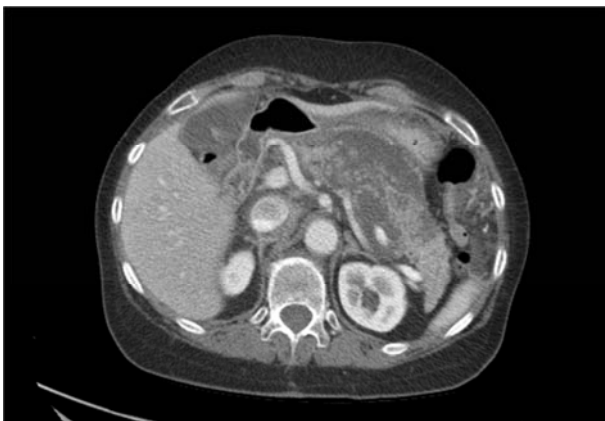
Initial CT Abdomen/Pelvis (4/2020) with evidence of pancreatic necrosis (note: absence of ascites or carcinomatosis at this point).
